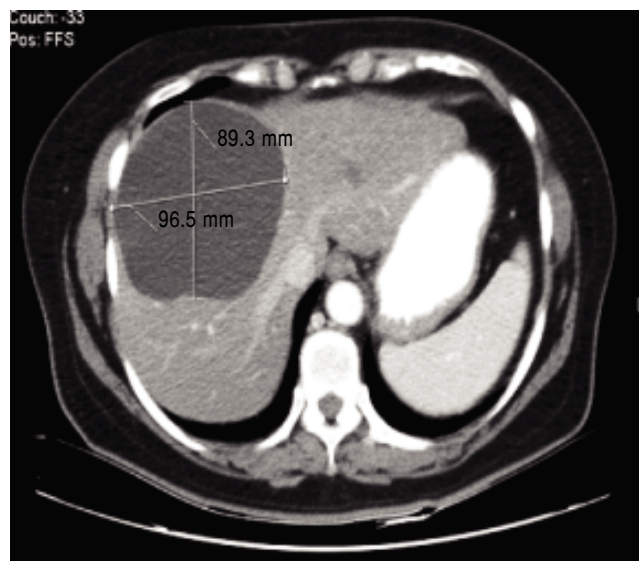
CT abdomen showing liver cyst 10 years prior.
